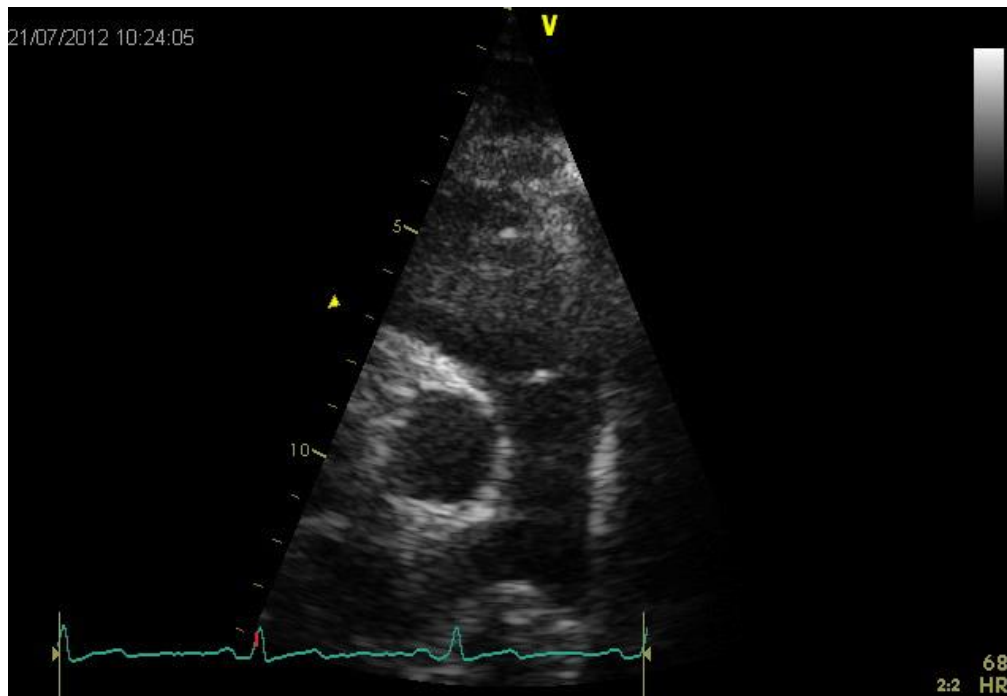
Pulmonary valve bifurcation view, optimised from a modified parasternal short axis view.
